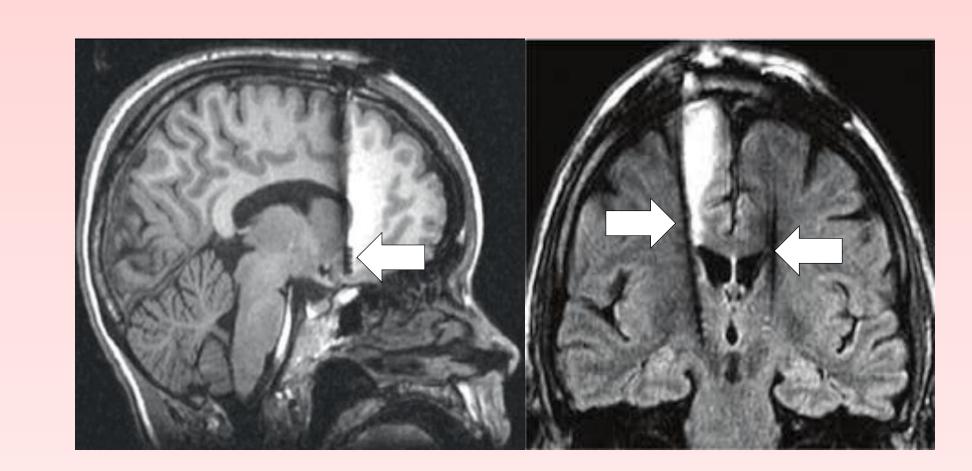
Sagittal (right) and coronal (left) MRI images of patients with DBS electrodes implanted. Differences in magnetic susceptibility between metallic electrodes and surrounding tissue create inhomogeneities in the magnetic field of the instrument, which manifest as distorted signal intensity and warping. Modified from Lipsman et al. 2013 (left) and Sarkar et al. 2014 (right).
